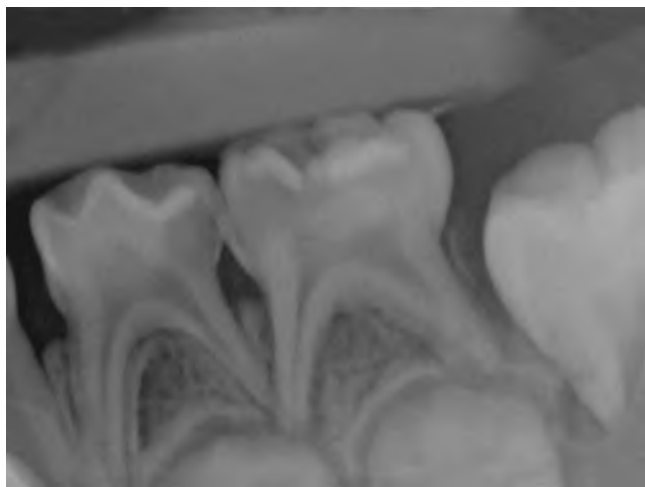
Periapical radiograph of primary mandibular left molars with deep caries. Note the recession of the distal portion of the pulp in the primary first molar as a defensive process from the carious injury.
